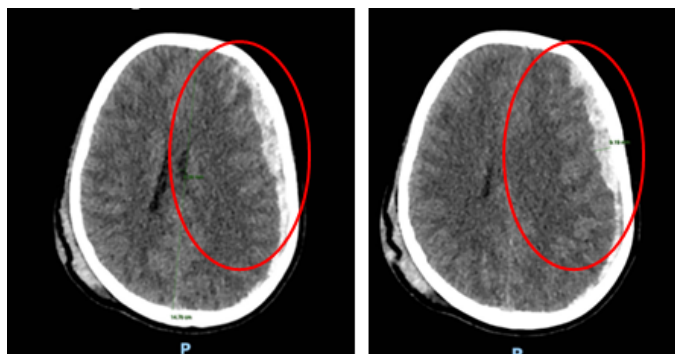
Head CT-Scan axial view
